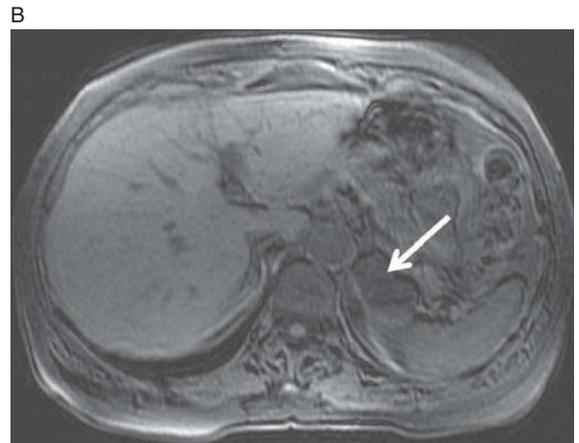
Adrenal cyst. This is really a great case. Axial T2-weighted image (A) shows a septated T2-bright mass in the left adrenal gland (arrow). This patient had been told that she had a pheochromocytoma and the mass had been followed for years. But, when a clever endocrinologist noticed that her biochemical profile was, and always had been, normal we decided to give gadolinium. Axial T1-weighted, fat saturated pre-contrast image (B) and post-contrast image (C) demonstrate no evidence of internal enhancement. Pheochromocytomas, despite being T2-bright, are solid masses and would therefore enhance.
